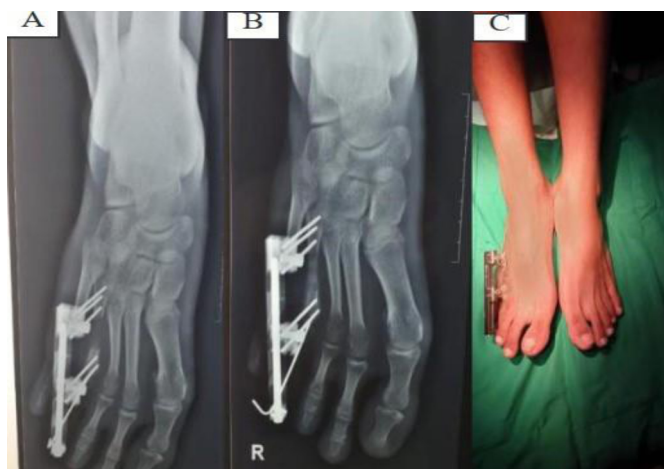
Radiography of bone lengthening for brachimetatarsia.²³
